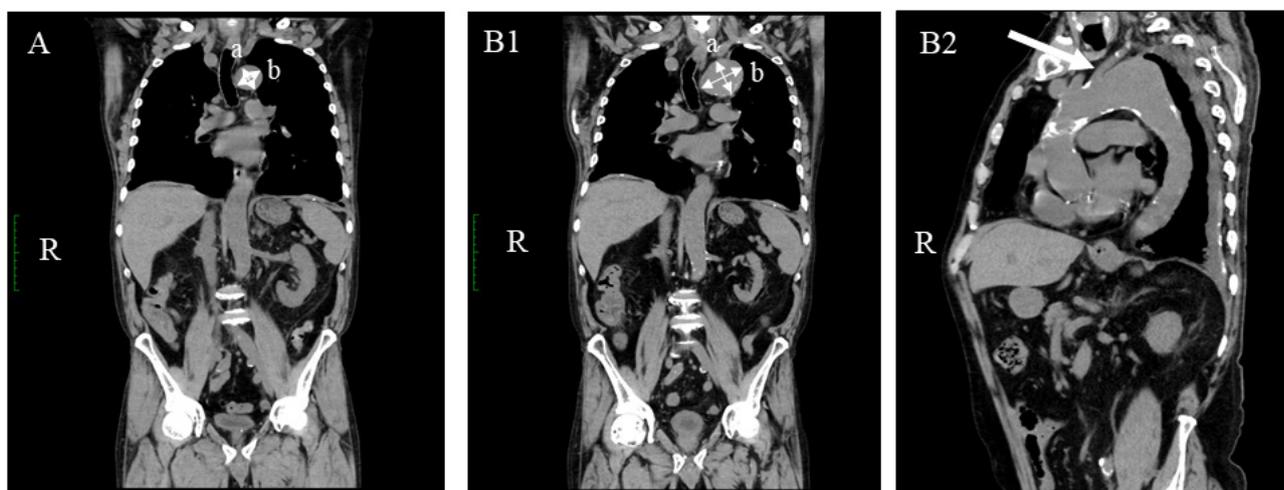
Plain CT images in coronal section and sagittal oblique reformation from the chest to the abdomen in Case 1.
